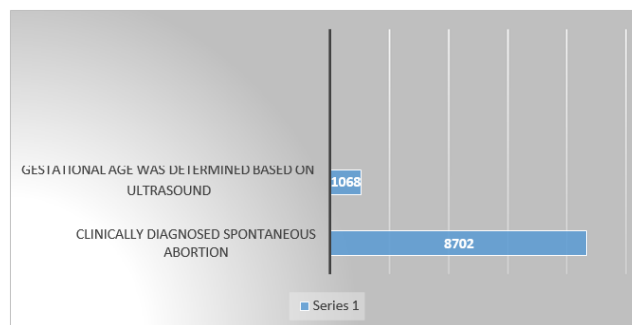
8702 (or 4.7% of them) of which resulted in a clinically diagnosed spontaneous abortion. In 1068 (12.3%) of the cases, the gestational age was determined based on ultrasound¹³
